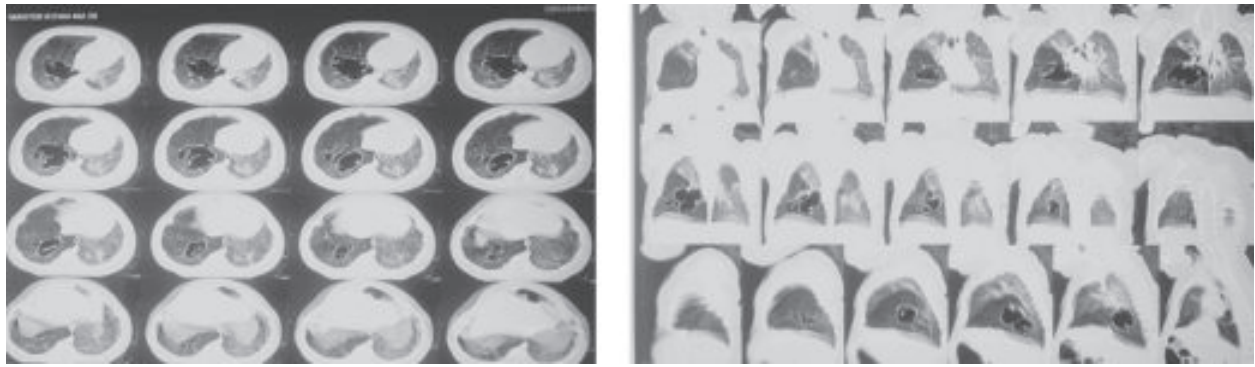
CT scan of the chest.*
